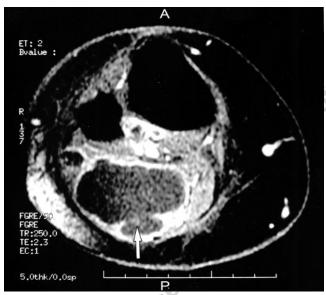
MRI axial view of the right lower extremity beneath the right knee joint with arrow pointing towards rim enhancing collection in the lateral gastrocnemius. A: anterior, P: posterior view of the right lower extremity.
